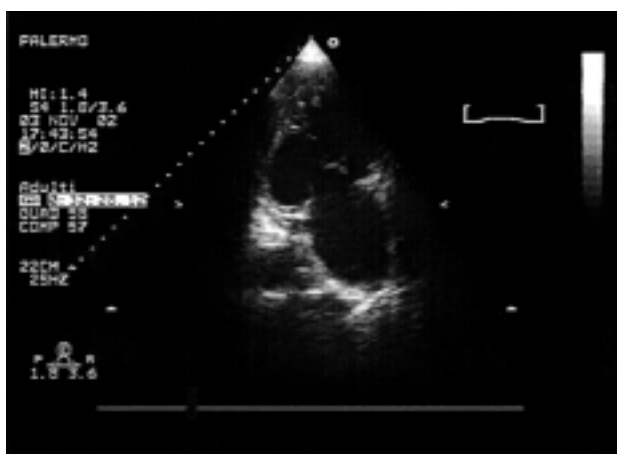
Transthoracic echocardiography. Note the aneurysm of the left ventricle involving the mid-basal segment of the postero-inferior wall and akinesia of the distal interventricular septum.
